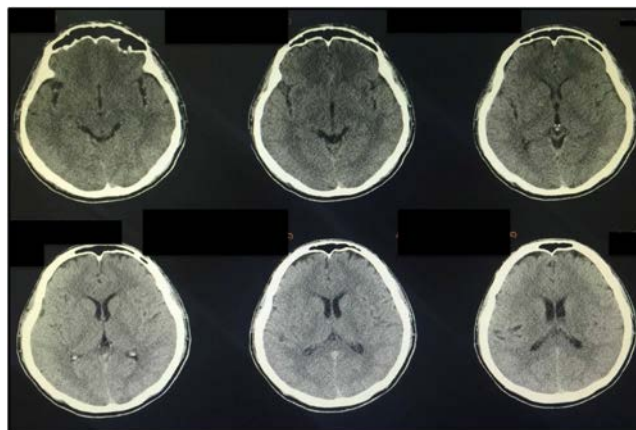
Cranial CT Scan
